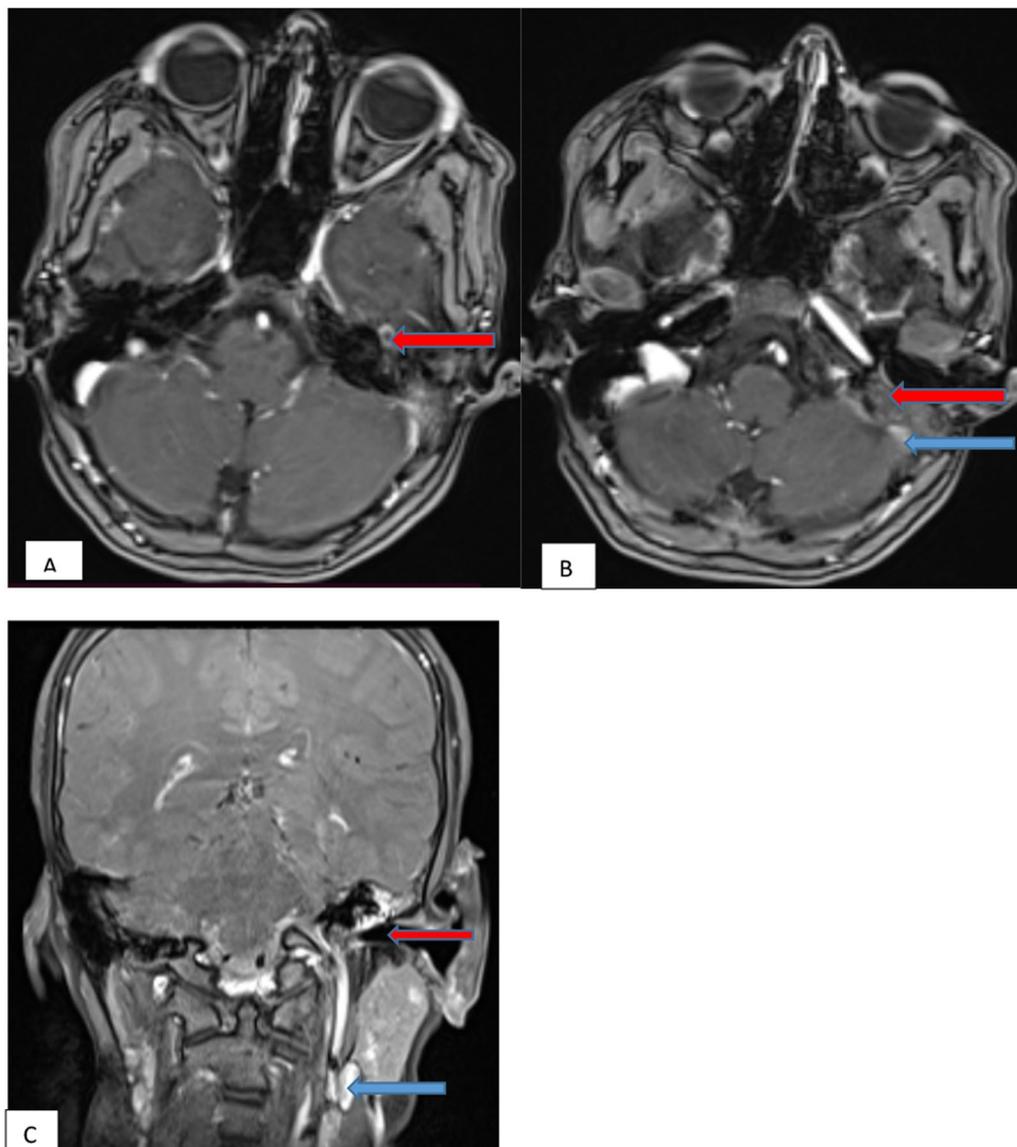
Post-contrast T1 fat-suppressed MR image at the base of skull after 6 months of treatment shows: A) Axial section: minimal residual enhancing collection in the petromastoid temporal bone with a significant interval reduction in its extension (red arrow). B) Axial section: Reduction in extension into the left cerebellopontine angle (red arrow) with narrow calibre and thrombosis of adjacent sigmoid sinus (blue arrow). C) Coronal section: resolution of soft tissue infiltration in left external auditory canal (red arrow) and reduction in enlarged left cervical lymph nodes (blue arrow)
